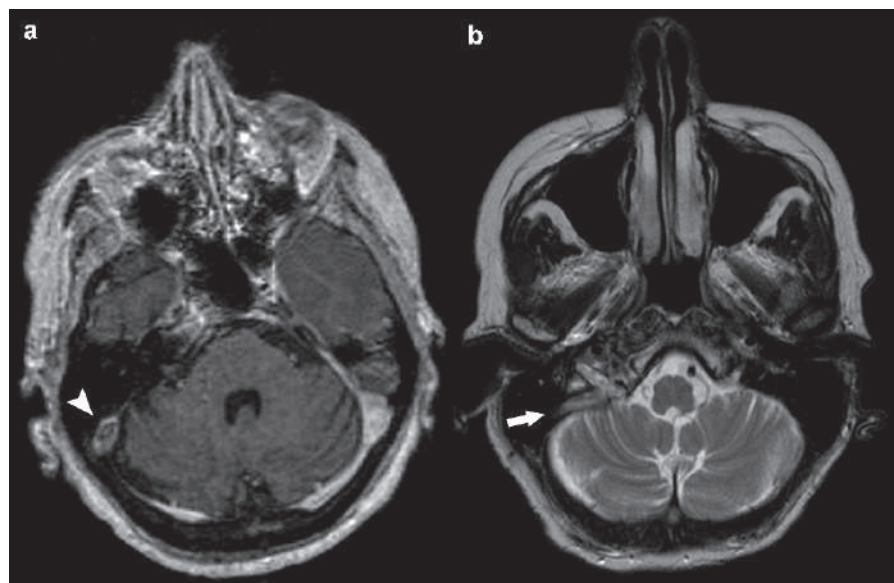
Axial T1W postcontrast (a) and T2W (b) brain MRI of a patient with ALL treated with chemotherapy, who developed right transverse sinus thrombosis, show filling defect in (a) (arrowhead), and hyperintense vessel in (b) due to the intravascular thrombus (arrow)
